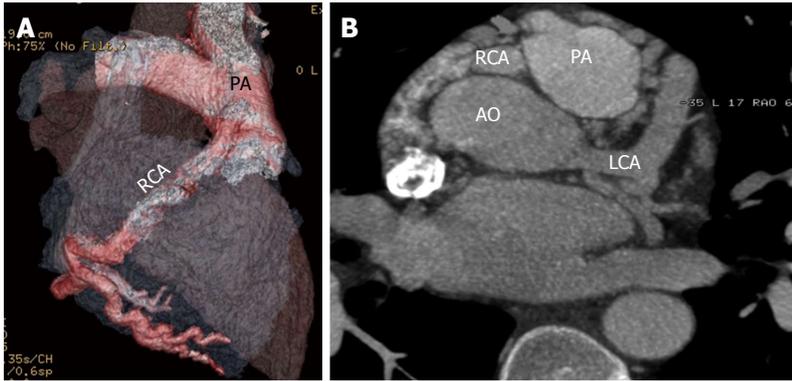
Anomalous origin of the right coronary artery from the pulmonary artery. A: reconstructed computed tomography angiography (CTA) image shows origin of the right coronary artery (RCA) from the main pulmonary artery (PA); B: Axial coronary CTA shows the origin of the RCA from the pulmonary artery. To compensate for this there is dilated left coronary artery (LCA), which provides collateral supply to the RCA circulation. AO: Aorta.
